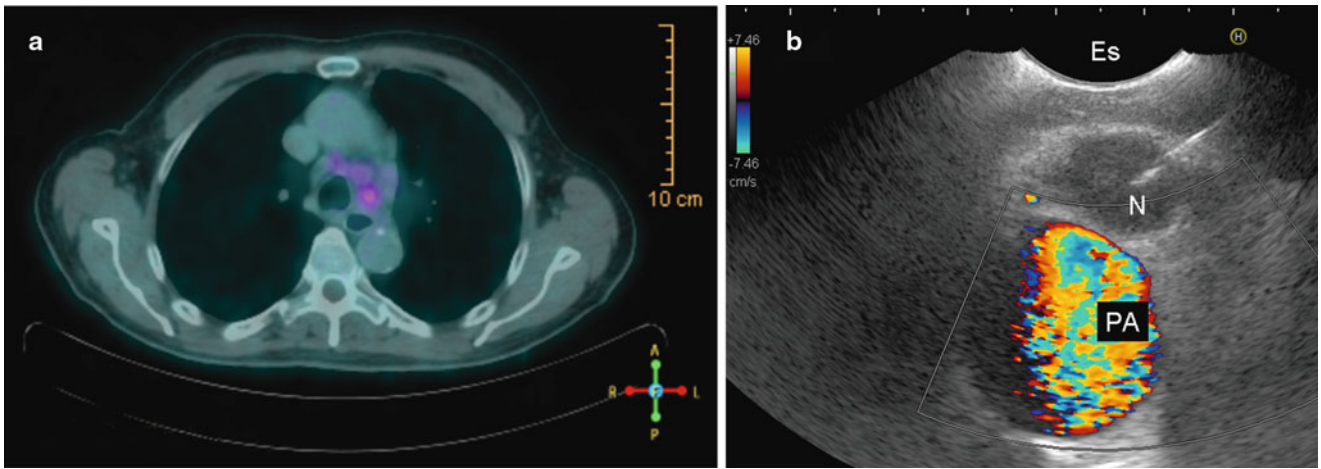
(a) Integrated positron emission and computed tomography (PET-CT) scan with FDG uptake in a lower left paratracheal node (station 4L). (b) Corresponding EUS-guided FNA (*N* needle) of the lower left paratracheal lymph nodes located between the esophagus (*Es*) and pulmonary artery (*PA*)
